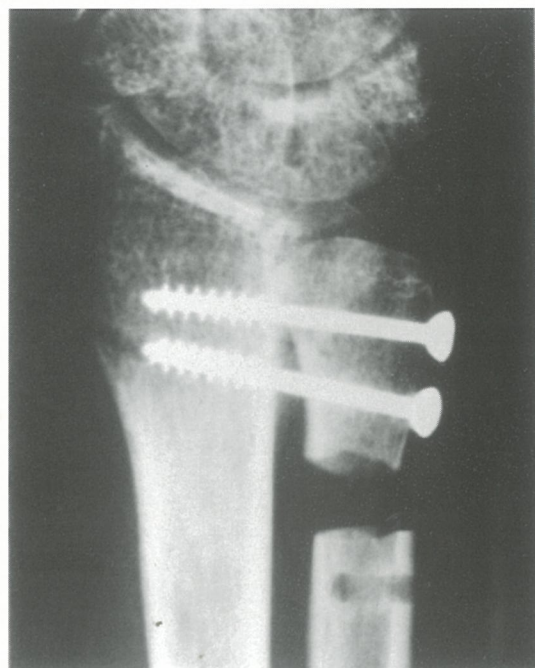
The immediate postoperative radiograph of Sauve-Kapandji operation showed fusion of distal radioulnar joint and creation of a pseudoarthrosis at the distal ulna.
